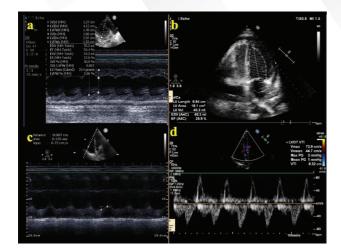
Bedside echocardiography at admission showed: a. non dilated LV; b. reduced LVEF of 26%; c. reduced TAPSE of 9 mm; d. reduced stroke volume with LVOT VTI of 9 cm
